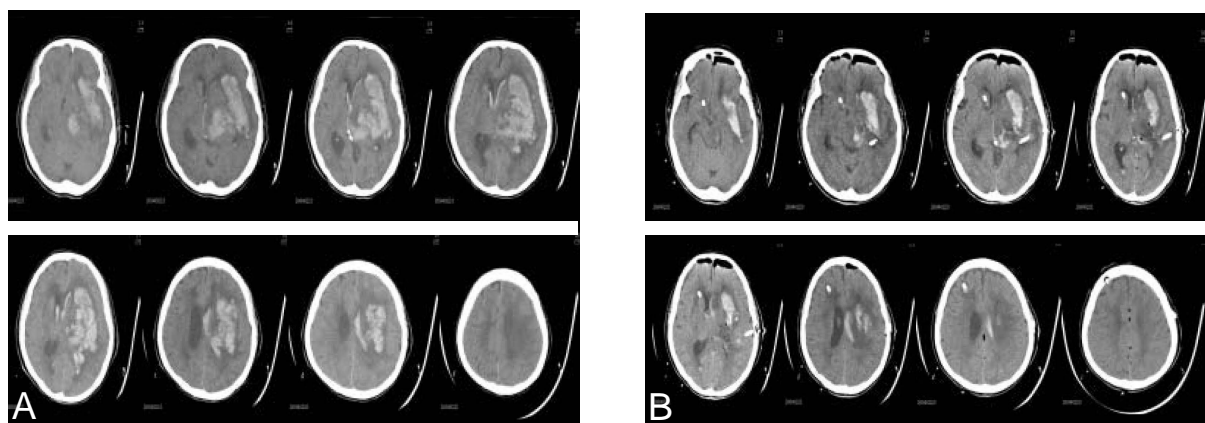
Patient 1: a 70-year-old woman presented with sudden disturbance of consciousness. A: CT scans at admission show left putaminal hemorrhage; the volume was 120 mL. B: Postoperative CT scans show only 40 mL hematoma remaining. (temporal approach)
